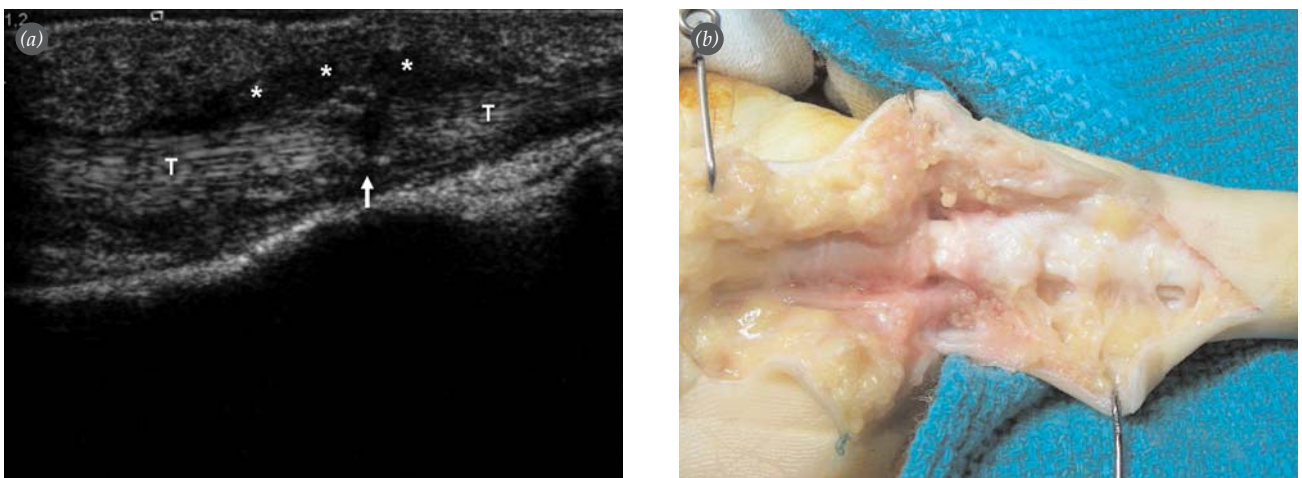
(a) A thickened adherent tendon surrounded by mixed echogenic fibrotic tissue in ultrasonography (asterisks). Suture material is seen within the rupture site as hyperechoic foci (arrow). T: proximal and distal ends of the tendon. (b) Surgical confirmation of tendon adherence.
